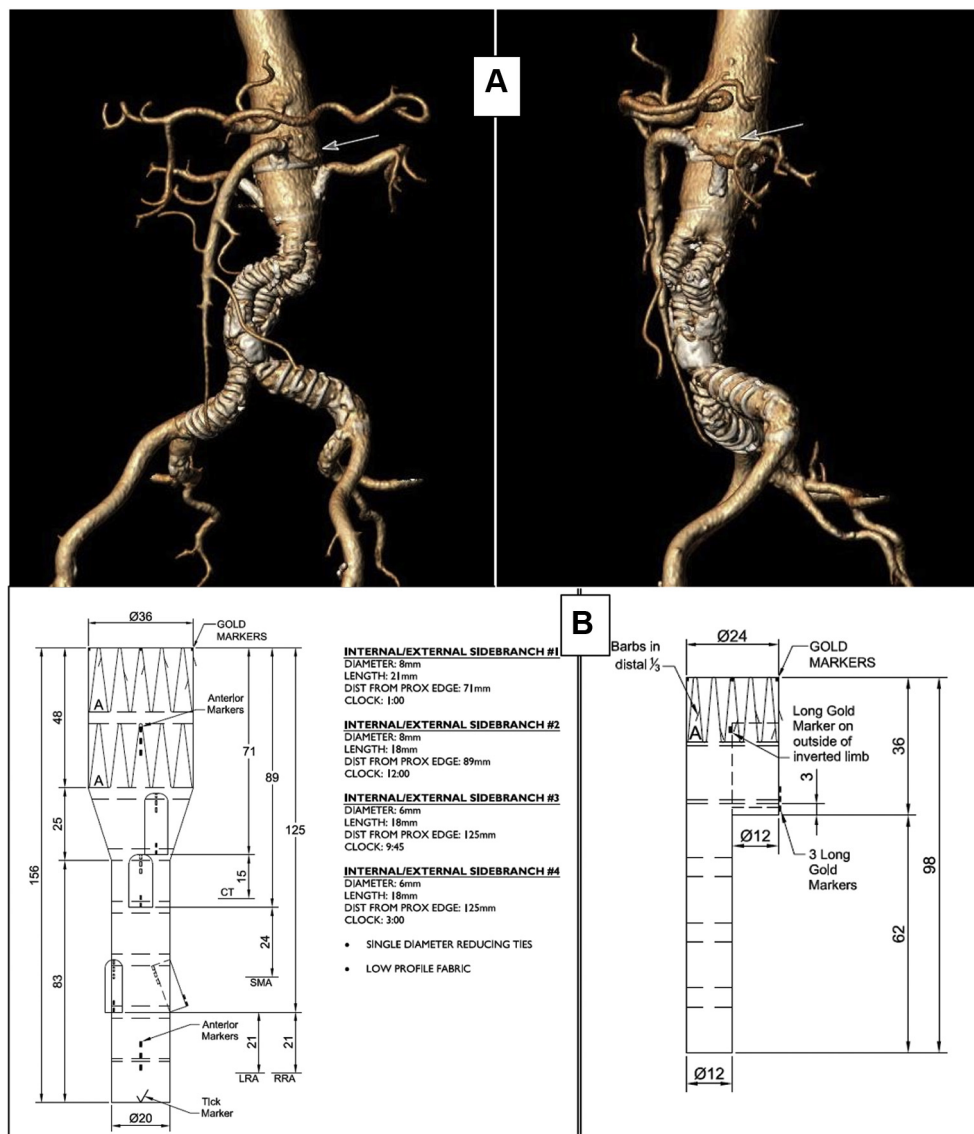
A, Three-dimensional reconstruction of 10-year follow-up computed tomography scan showing distal migration of the previous device, severe angulation of the renal stents, and a proximal type I endoleak (arrow). B, Case planning for a branched endograft and bifurcated body with an inverted contralateral limb.
